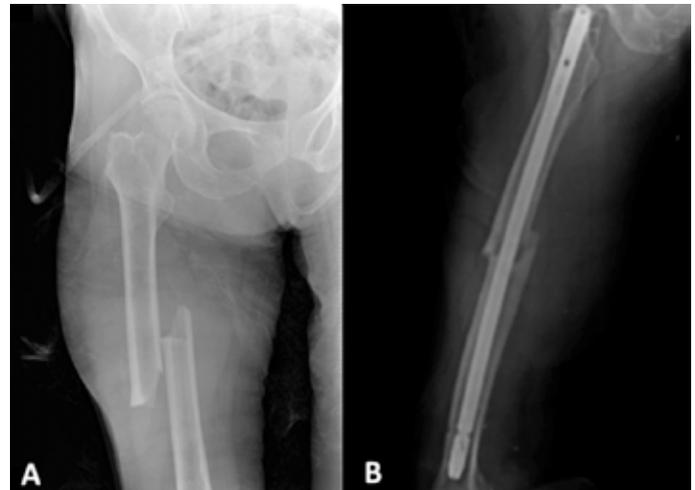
Right femur shaft fracture (A), Post-operative X-ray (B).
